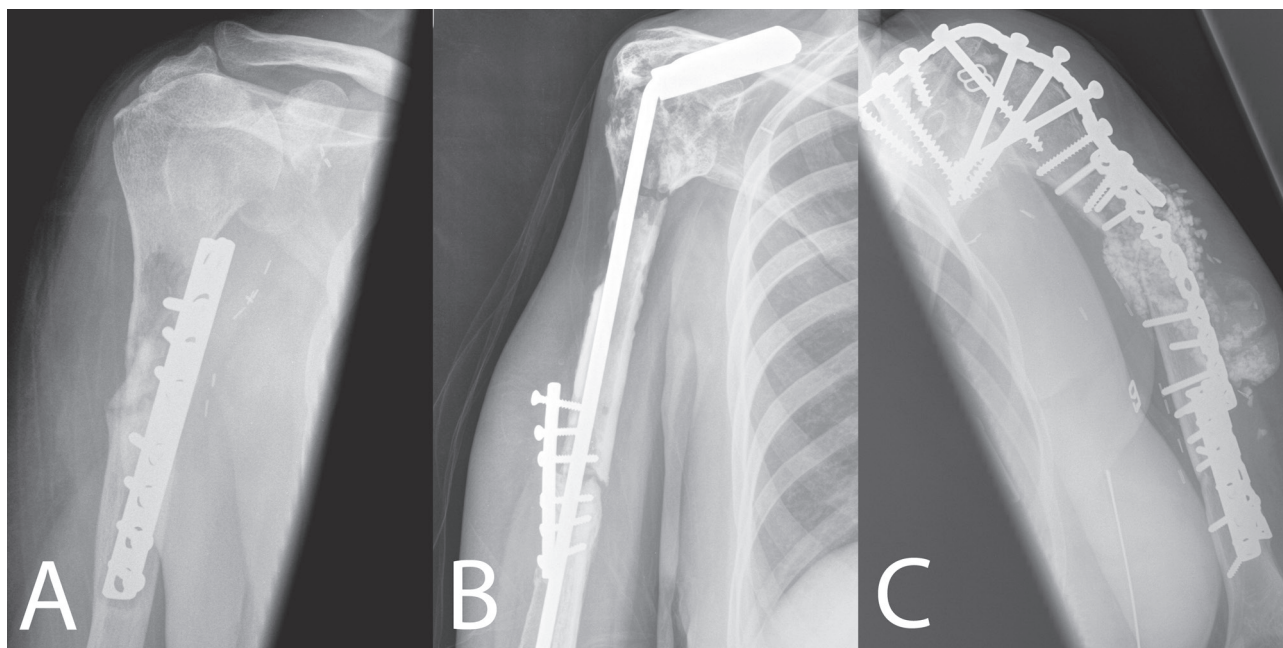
Radiographs demonstrating modes of failure ; A : non-union, allograft resorption, and fracture, B : non-union secondary to infection, C : massive infection with metalwork failure.
